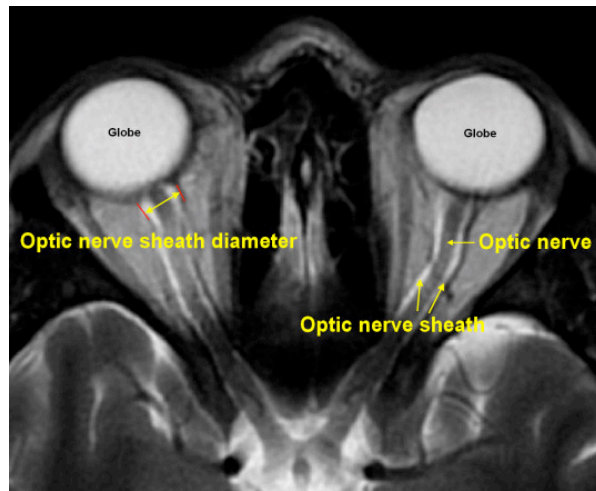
Magnetic Resonance imaging of the optic nerve and optic nerve sheath diameter.
